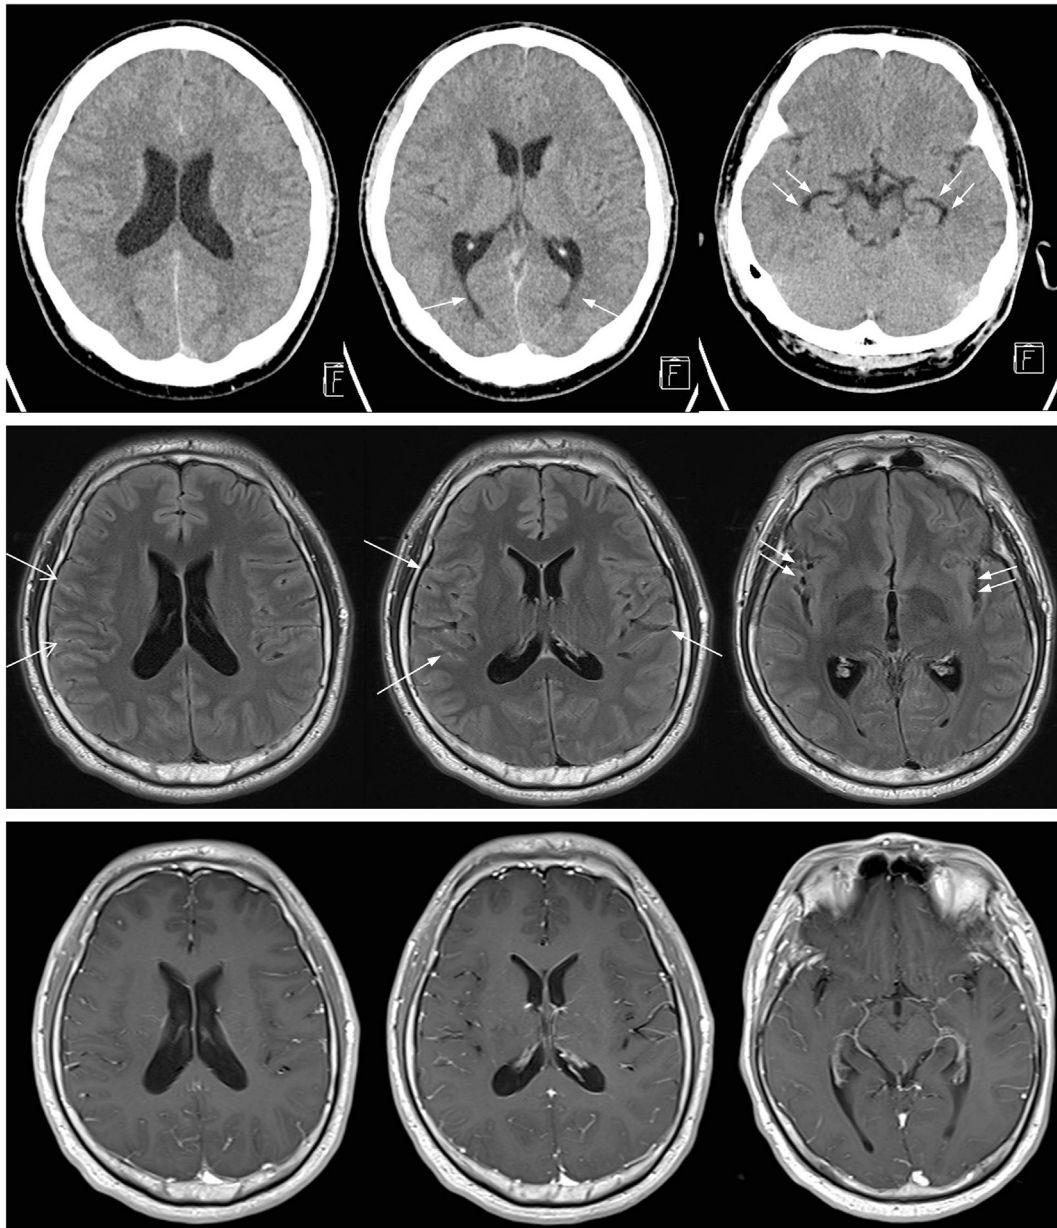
NTM meningitis, presenting as hydrocephalus, in a 30-year-old male. (Upper panel) The initial brain CT scan showed subtle enlargement of both lateral ventricles including both occipital horns (arrows) and both temporal horns (double arrows). (Middle panel) Brain MR images of NTM meningitis showed bilateral sulcal hyper-intensity signals in the frontoparietal lobe (long arrows) and sylvian fissures (double arrows) on CE-FLAIR images. (Lower panel) Enhanced T1WI showed no demonstrable leptomeningeal enhancement.
